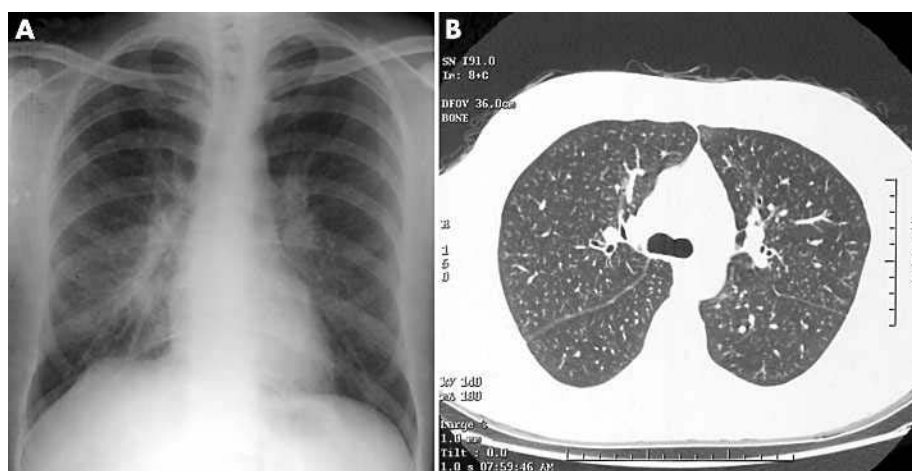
(A) Chest radiograph in case 3 with chronic hypersensitivity pneumonitis showing bilateral hilar enlargement and micronodular pattern in paracardiac region. (B) High resolution chest computed tomogram in case 3 showing bilateral micronodular interstitial infiltrations and nodules seen on both thick major fissures.
